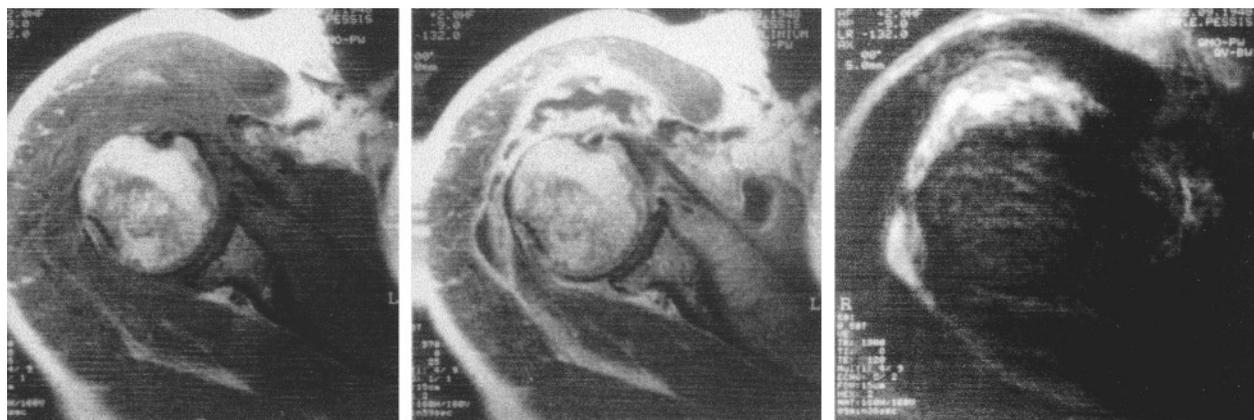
Shoulder MRI, case 11. Axial section (left to right: T1, T1 with gadolinium, T2). A huge deltoid bursitis was noted. The signal of the hypertrophic synovium was as described in Figure 2, with more intense enhancement with gadolinium. Extensive effusion of the deltoid bursa was observed, but no abnormal feature was present within the joint.
